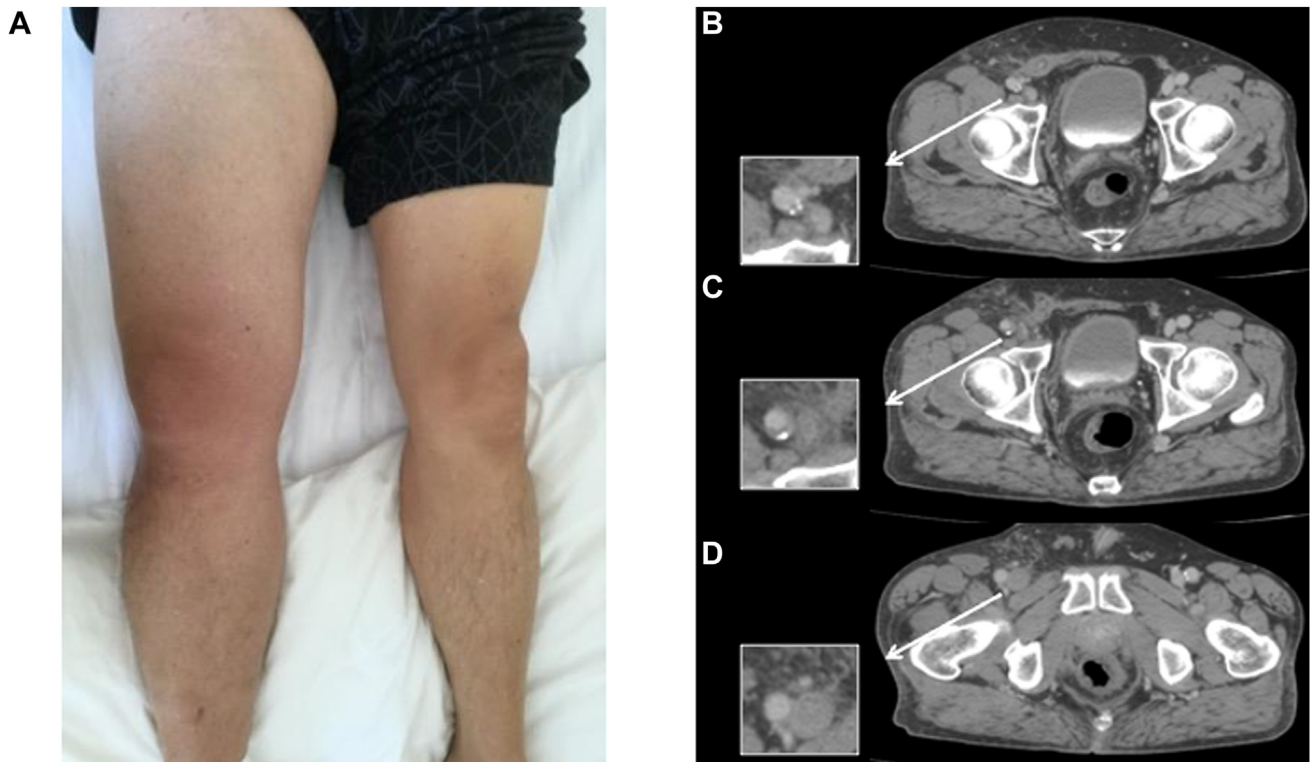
A: Gross appearance of the lower extremities on postablation day 3. B–D: Enhanced computed tomography from proximal to distal with magnified view of the right femoral vein and artery. At the level of the puncture site (C), the venous lumen was elliptic without enhancement. Distal to the puncture site, the vein was dilated (D).
